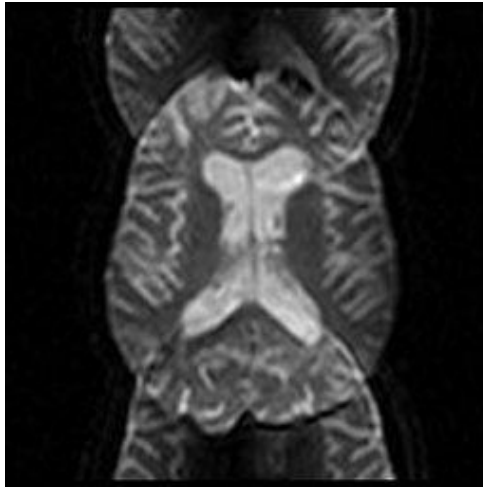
Nyquist ghosting in MR imaging using EPI pulse sequences.
